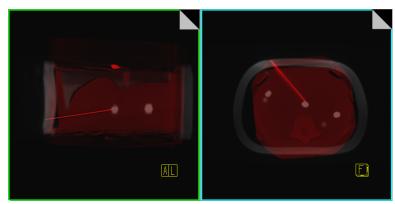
Screenshot of the fused MR image before the puncture and the CACT dataset (red overlay) after the puncture (coronal and axial view). The real needle (bright red overlay) is located in the center of the cyst.
